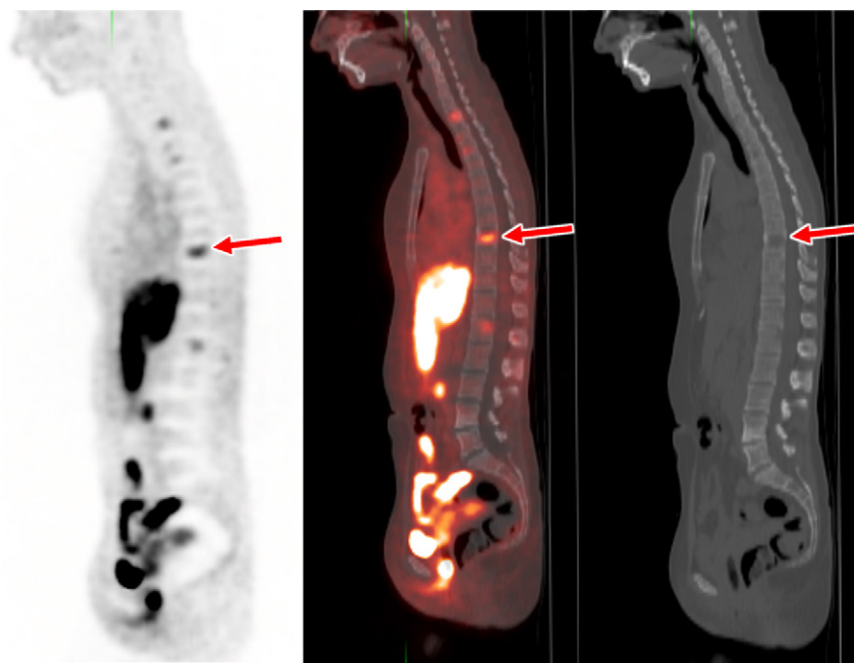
Metastatic ER-positive poorly differentiated invasive ductal carcinoma in a 35-year-old woman. Sagittal FES PET (left) and sagittal fused FES PET/CT (middle) images show abnormal FES uptake (arrows, left and middle) in multiple vertebrae, which are easily identified among the non-FES-avid normal vertebrae. Sagittal CT image (right) shows lucent lesions (arrow, right) corresponding to the abnormal FES uptake. FES uptake in osseous structures is easily characterized as metastasis even without a corresponding CT abnormality, because degenerative osseous disease does not demonstrate FES avidity. Although bone biopsy was not performed, the patient had years of clinical and imaging follow-up that demonstrated ER-positive osseous metastatic disease (SUV scale, 0–5).
